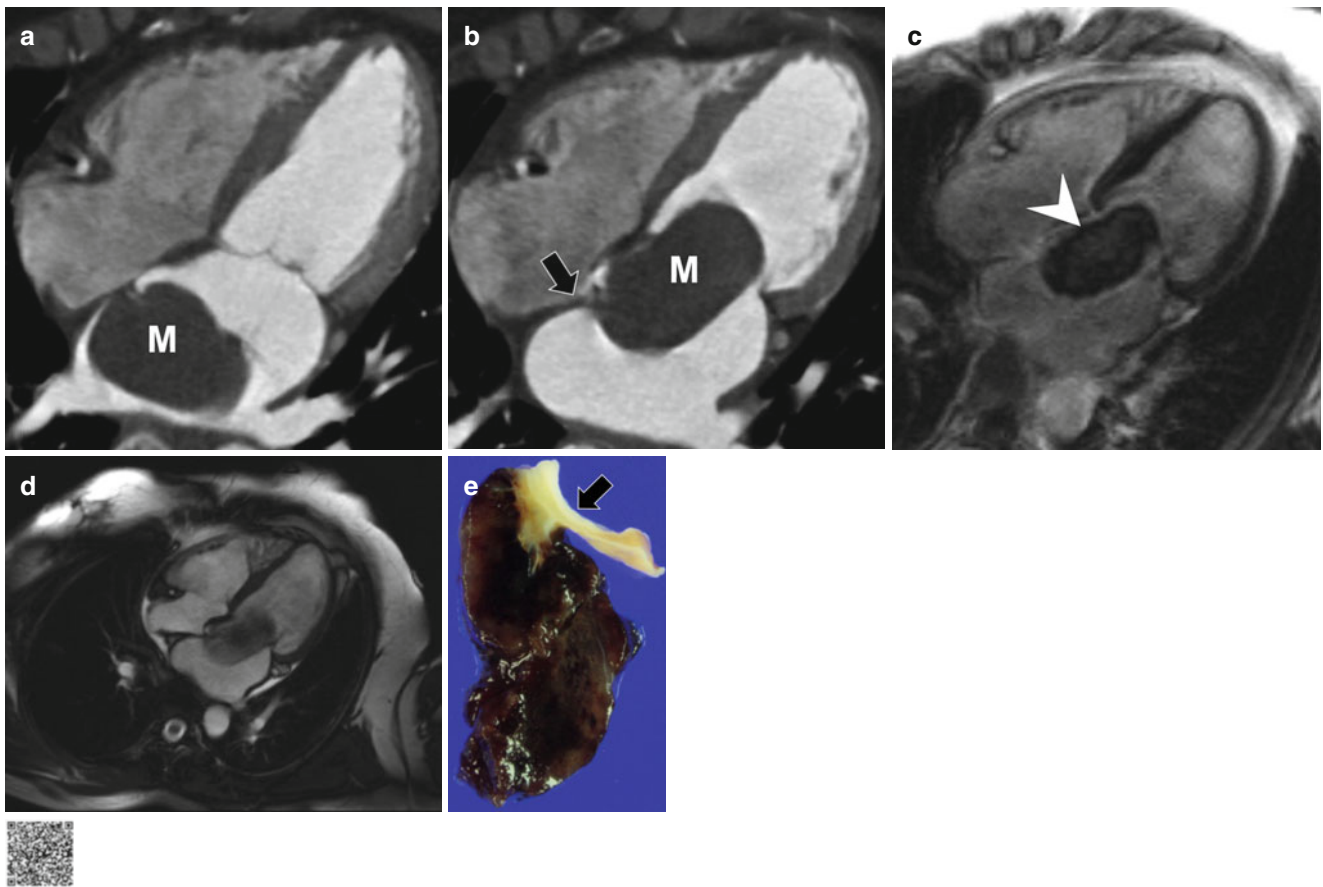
Large myxoma resulting in mitral stenosis. (a, b) Four-chamber view of CT images (a, systolic; b, diastolic) shows a large low-density mass (*M*) in the left atrium, attaching interatrial septum (*arrow*). In diastolic phase, inflow tract of the left ventricle is obstructed by the huge mass. (c) Four-chamber view of delayed enhancement MR image shows ill-defined contrast enhancement (*arrowhead*) in the central
